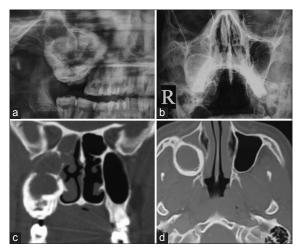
Case 2 (a) cropped orthopantomograph image. (b) Cropped paranasal sinus view image. (c) Coronal section of computed tomography. (d) Axial section of computed tomography
